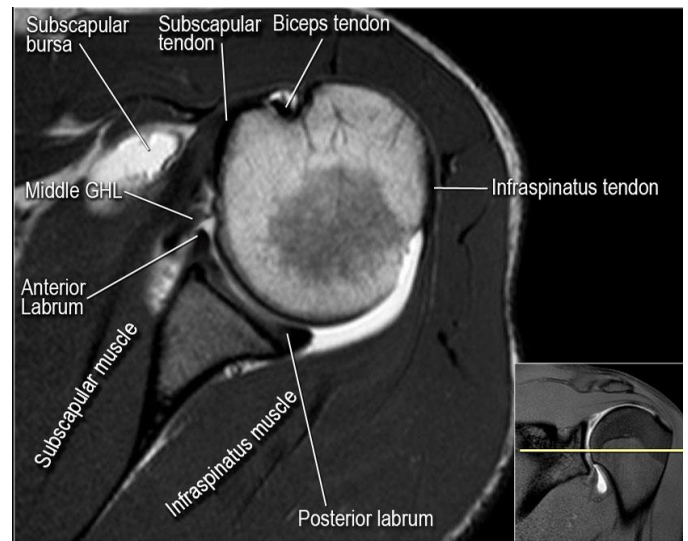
Axial shoulder MRI
